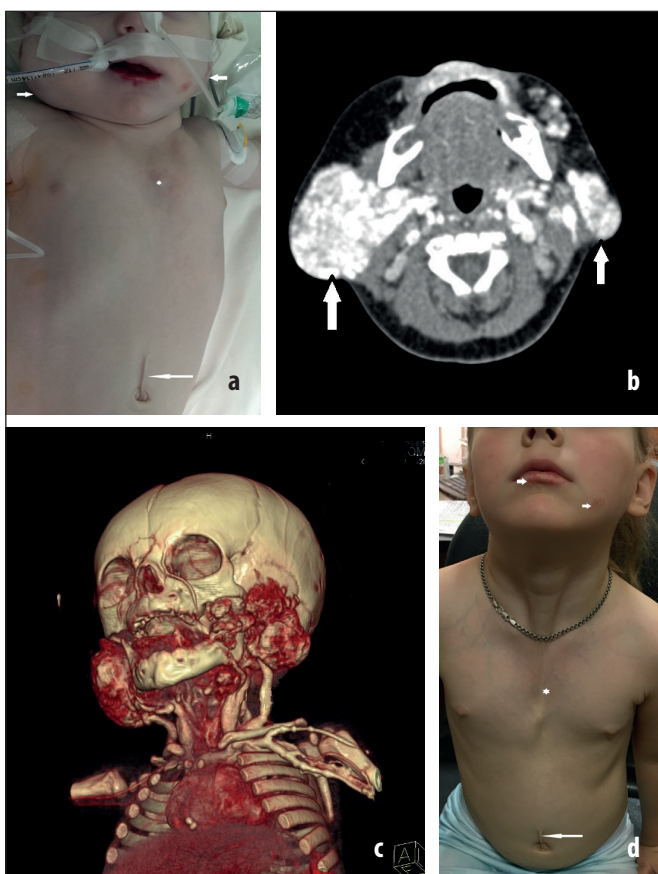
a-d Patient with S3 bilateral hemangioma, subglottic hemangioma with stridor, sternal cleft, and supraumbilical raphe. Picture before treatment (a). CT with intravenous enhanced (b). CT: 3D reconstruction shows the extension of hemangioma (c). Picture after treatment; 3 years old (d).
